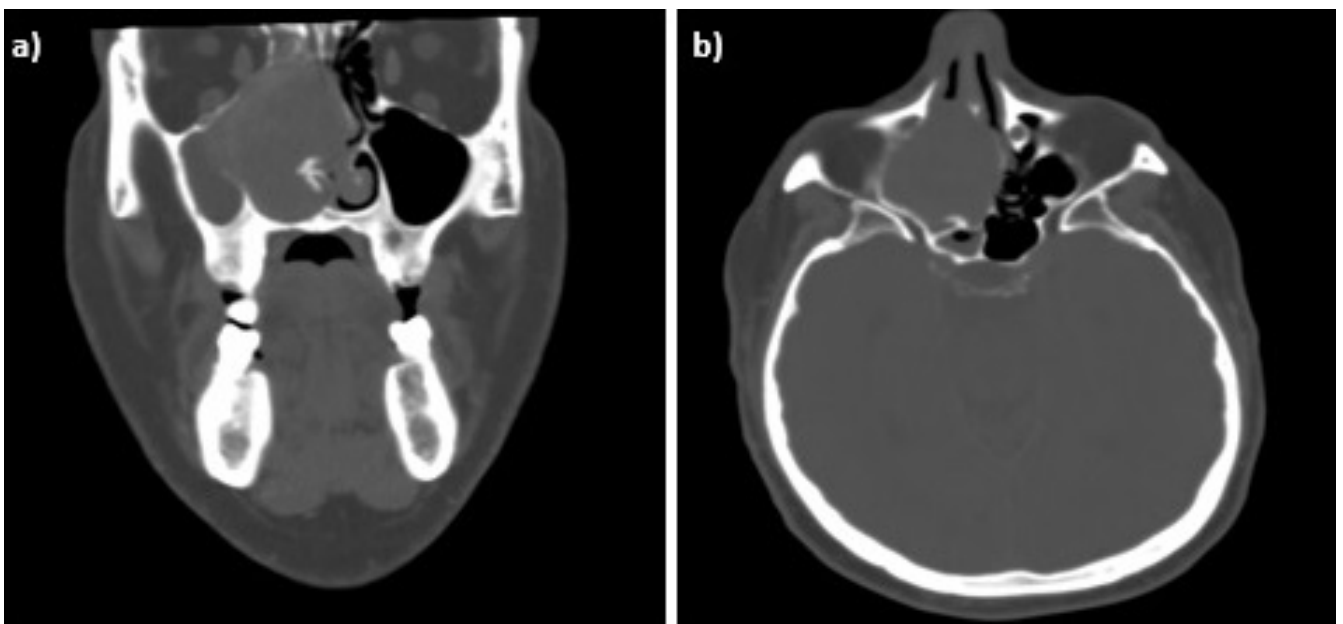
CT image of the SFT in coronal section (a) and axial section (b)
